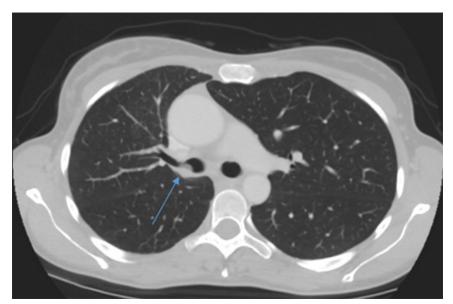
Thoracic computed tomography scan showing the bronchial tumor (*arrow*) starting from the lobar bronchus of the right lower lobe. Extension to the middle-lobe bronchus cannot be ruled out.
